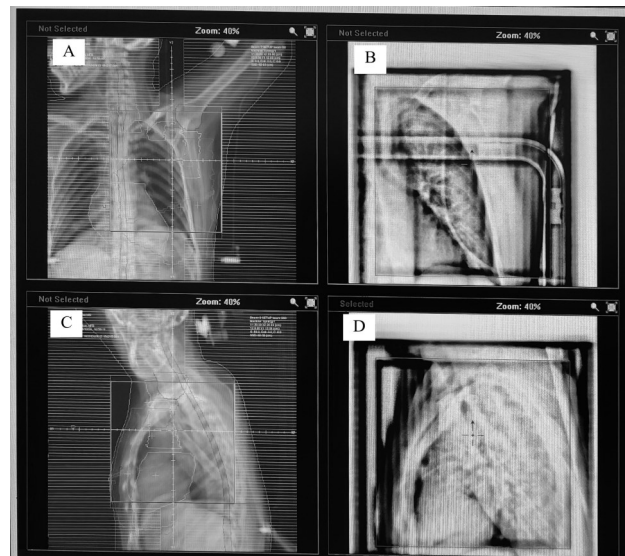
DRR (Digitally Reconstructed Radiograph) and portal images which were exported from the TPS (Treatment Planning System) and mosaic systems, respectively: AP DRR image (A), AP EPID (Electronic Portal Imaging Device) image (B), lateral DRR image (C), lateral EPID image (D).
